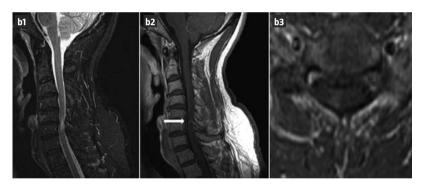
Magnetic resonance imaging examination 6 months later showed a lesser swelling in T₂-sequences (b1), and persistence of the enhancement (b2, arrow; and b3).
